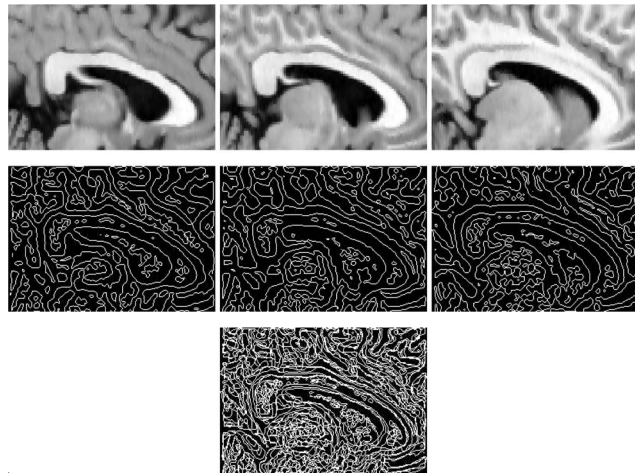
The top row are the original sequential MR images; the second row are their closed contours, which form super-vertices; the bottom plot is the final super-vertices for the three images.
